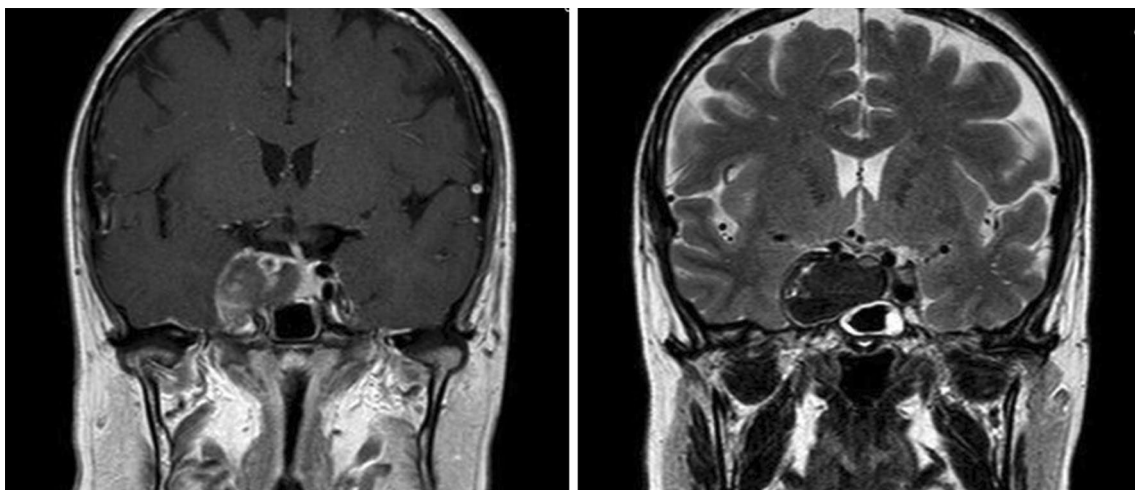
Pituitary MRI images of a 60 year-old female patient. A large (3×2×2 cm) mass lesion had iso- and hyperintense areas on T1-weighted and iso- and hypointense areas on T2-weighted images. Aneurysmatic rupture obliterated right cavernous sinus and caused
